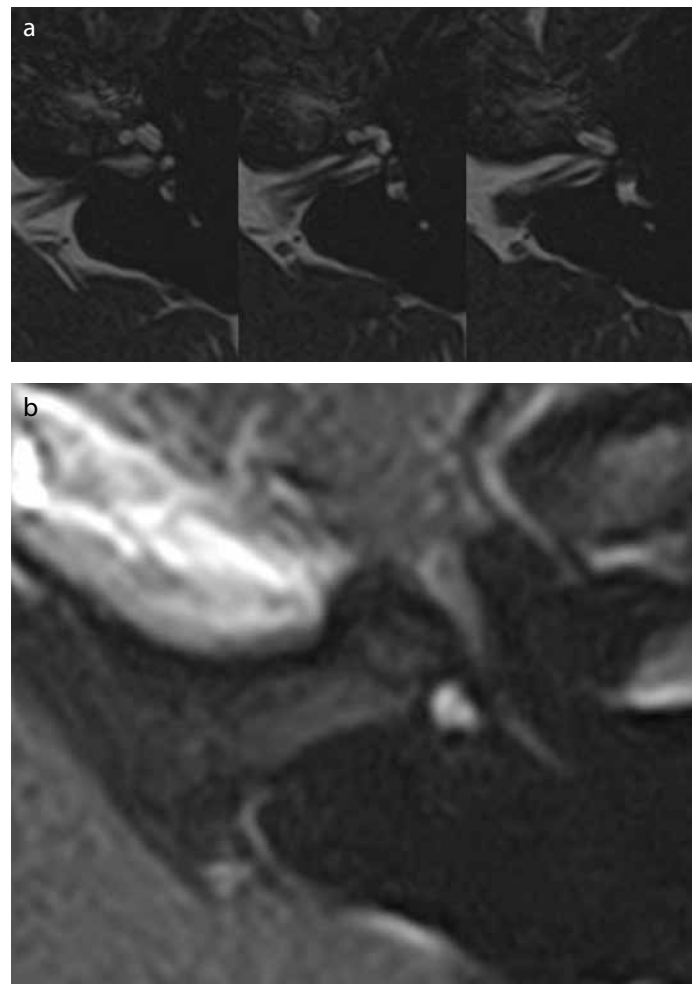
a, b. (a) Axial T1-weighted MR images show noticeable nodular vestibular mass enhancement after contrast administration. (b) Axial T2-weighted MR images of the internal auditory canal, cochlea, and eighth cranial nerve. It is possible to identify a lack of natural hyper-intense signal in the vestibule due to the presence of a small nodule.
